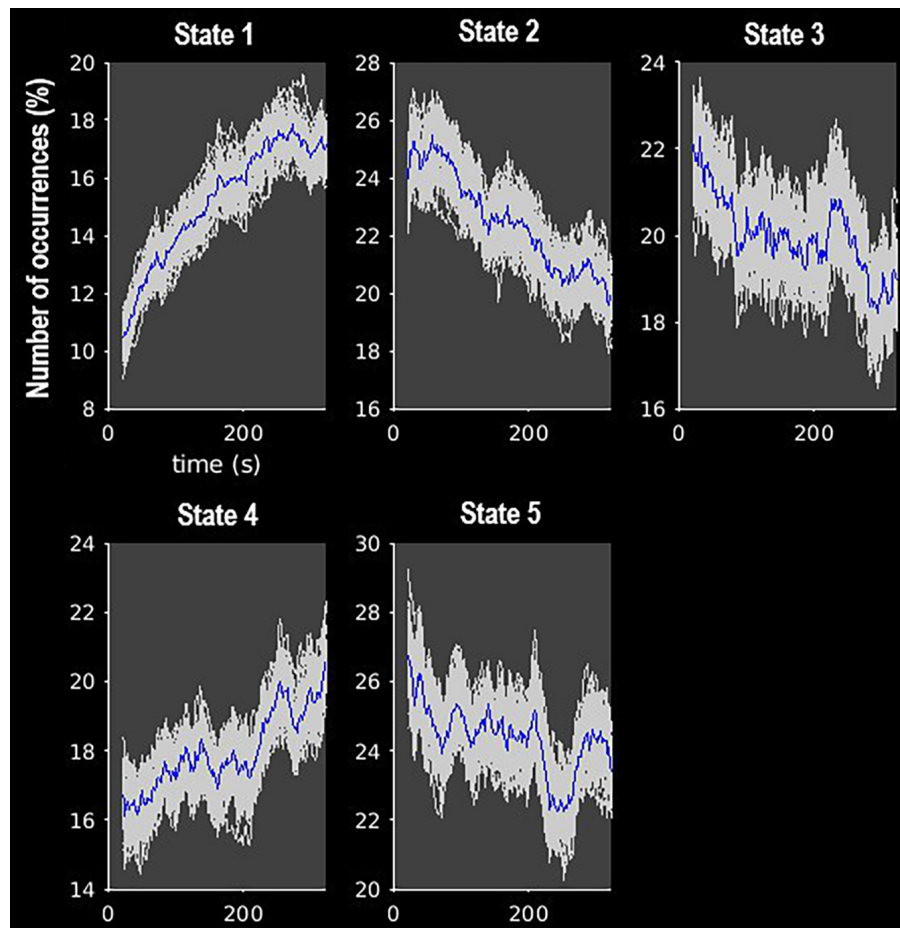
Frequency of occurrence of each state over the course of the MRI scan. Gray lines indicate the estimated occurrence profiles of each state for 100 bootstrap resamples with replacement.
